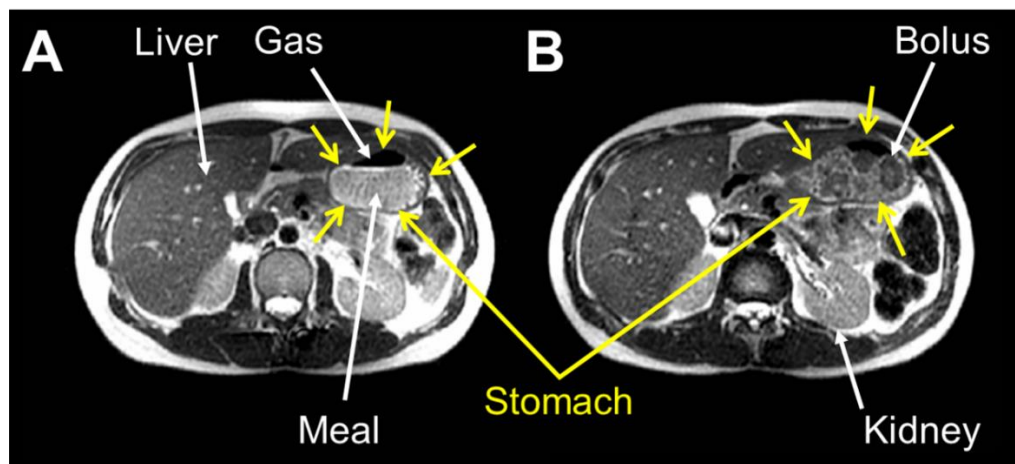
(A) MRI image acquired axially through the stomach of a study participant at T=90 minutes after feeding the rice control meal. (B) Corresponding MRI image from the same participant taken at the same time point but after consuming the rice + low acyl gellan gum (LAGG) meal. In (B) darker, round boluses are visible inside the stomach. Anatomical landmarks such as the liver and kidneys are also indicated by white arrows for ease of orientation.
